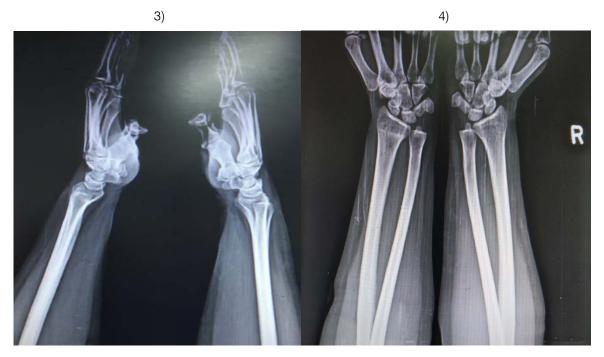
A. shows Kapandji technique 1) pre op radiographs, 2) immediate post op radiographs, 3), 4) 6 months follow up radiographs compared to opposite non fracture side. B. shows Extra Focal technique 1) pre op radiographs, 2) immediate post op radiographs, 3), 4) 6 months follow up radiographs compared to opposite non fracture side.
